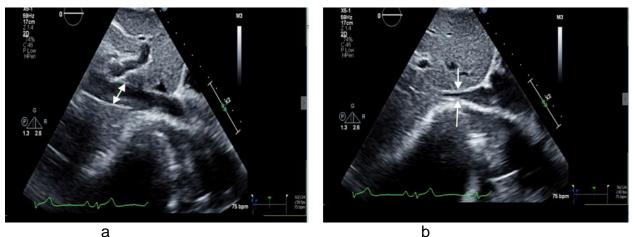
5: Echocardiography displays a significant reduction in vessel lumen diameter on inspiration with Valsalva manoeuvre, a) expiration b) inspiration. Inferior vena cava diameter reduced from 1.5cm to 0.6cm.
